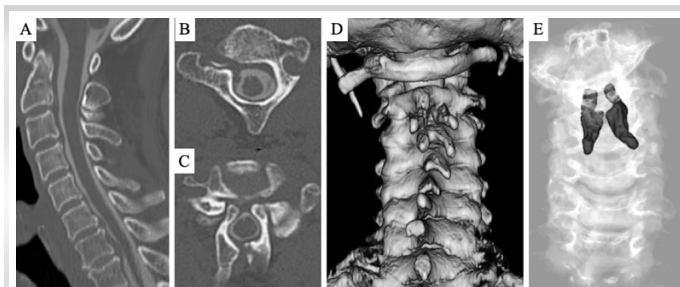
Pre-operative computed tomography. (a) Mid-sagittal, (b) axial at C2 lamina, (c) axial at C2-3 level, (d) three-dimensional image, and (e) three-dimensional image with an anomalous bony structure.
